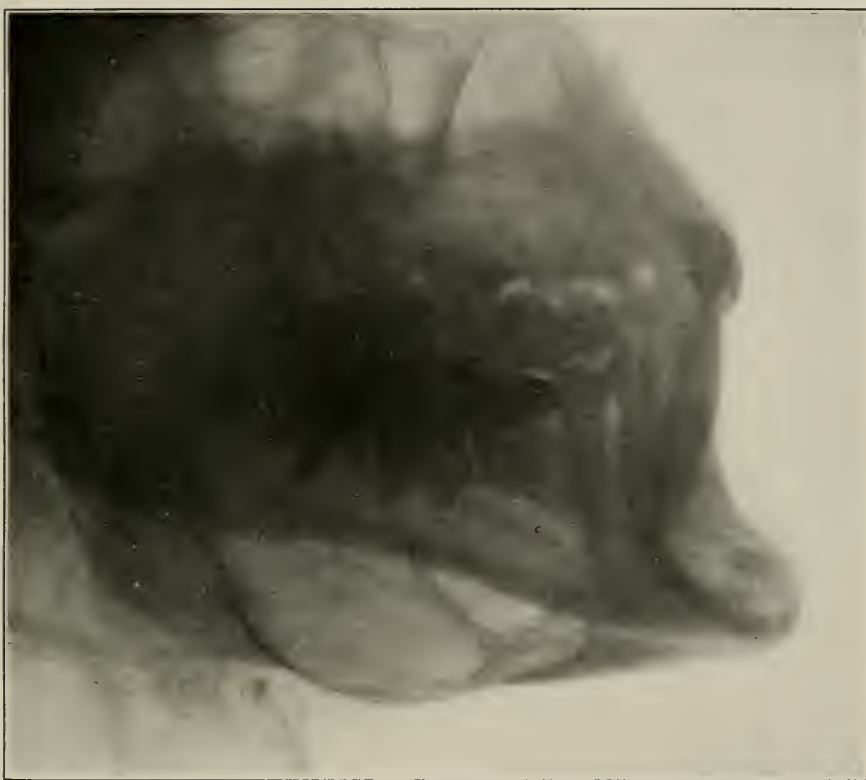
A very large cyst of the lower jaw. The light area represents the cyst. This radiograph shows the hyoid bone. (Radiograph by Lange, of Cincinnati.)
